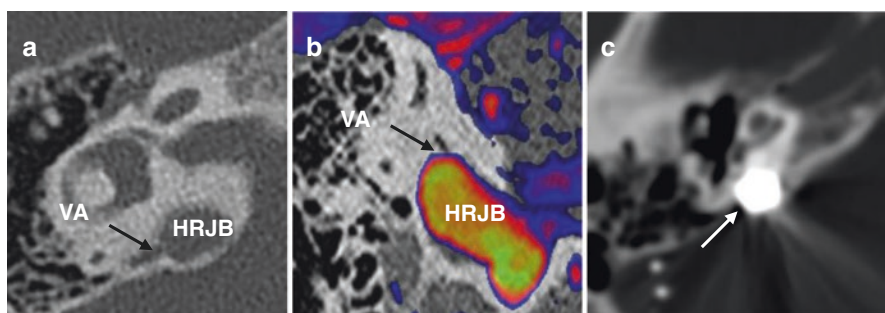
(a) right axial petrosal bone high-resolution computed tomography (HRCT). VA in contact with HRJB (black arrow). (b) Fusion between HRCT and 3D T1 weighted enhanced sequence of the right petrosal bone—coronal. (c) CT—control post treatment: metallic artifact image due to the coils in contact with the right bony labyrinthine structure
